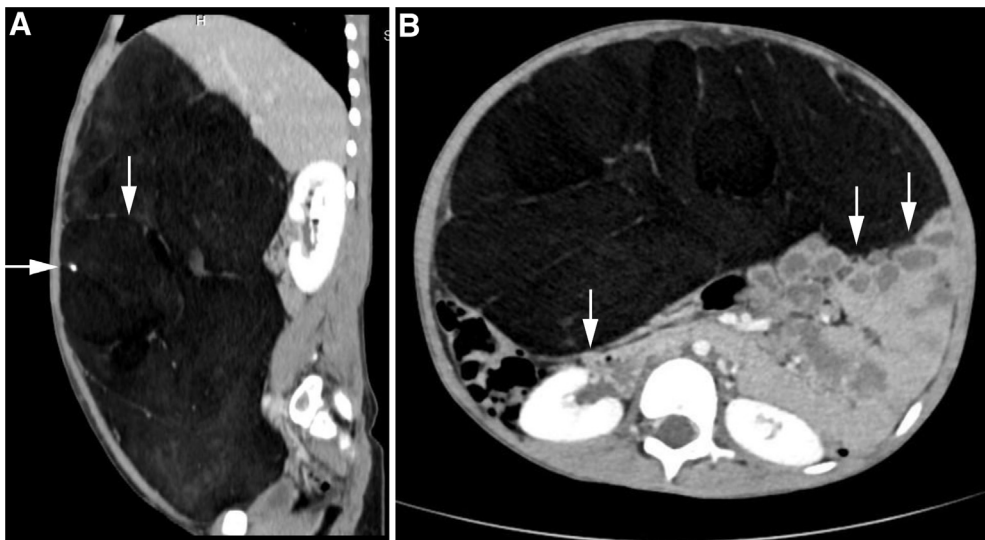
(A) Contrast-enhanced right parasagittal CT section through the abdomen and pelvis shows a huge, well-defined, low density, nonenhancing, intraperitoneal, mass lesion extending from the diaphragm down to pelvis. Note the fibrous septa and a calcified focus (arrow). No evidence of inflammatory reaction or infiltration of surrounding structures. (B) Contrast-enhanced axial CT section through the abdomen and pelvis: The well demarcated, low attenuating mass lesion is compressing the bowel loops rather than infiltrating them (arrows). No extension to the retroperitoneal spaces. The retroperitoneal structures and the bowel loops are displaced posterolaterally (arrows). No evidence of any obstructive compression on gastrointestinal or urinary tract organs.
